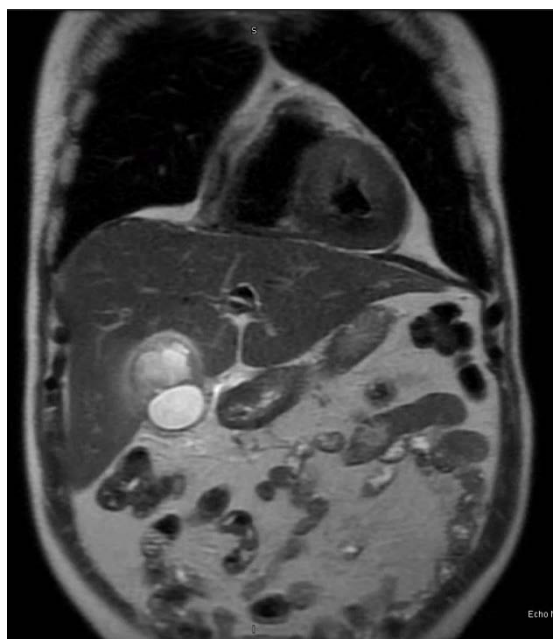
Coronal CT image of the patient showing a perforated gallbladder
